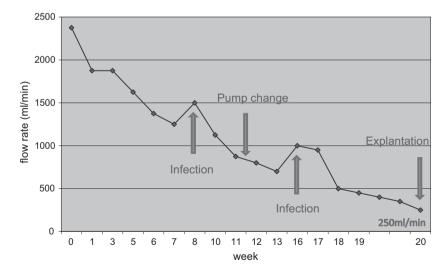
RVAD weaning process over 20 weeks. Reduction of pump rate by a maximum of 10 beats per min per week, using echocardiographic guidance, ensuring improvement of RV function and hemodynamic stability. Pump change after 11 weeks from a 25-ml to a 10-ml pump to avoid thrombus formation. Continuation of the weaning procedure until a minimal safe flow rate of 250 ml/min. After 20 weeks, the RVAD support was completely turned off. Controlled by echocardiography, the device was manually operated by a hand pump once every minute for a period of 15 min to prevent clotting, followed by RVAD explantation 2 days later.
